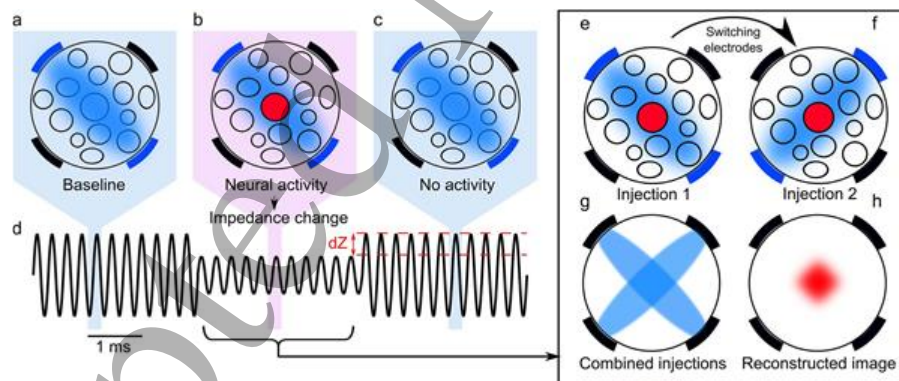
The principle of fast neural EIT in a ‘model’ peripheral nerve. (a)–(d) The impedance change occurs during neural activity (b) with respect to the background (a) and (c), which is measured by passing a constant current through a pair of external peri-neural electrodes and recording the voltage response on the remaining electrodes (d). Typically, cuffs have 16–32 electrodes; just 4 are shown here for explanatory purposes. (e) and (f) The pair is then switched from one to another and the paradigm is repeated covering all possible electrode combinations. (g) These measured transfer impedances can be reconstructed into tomographic images using principles similar to x-ray back projection. (h) Reconstructed images of the neural activity have a resolution of less than 100 μm and 0.3 ms with current methods using 6 kHz applied current and 16 electrodes in a nerve 1.5 mm in diameter. Reproduced from [86].
